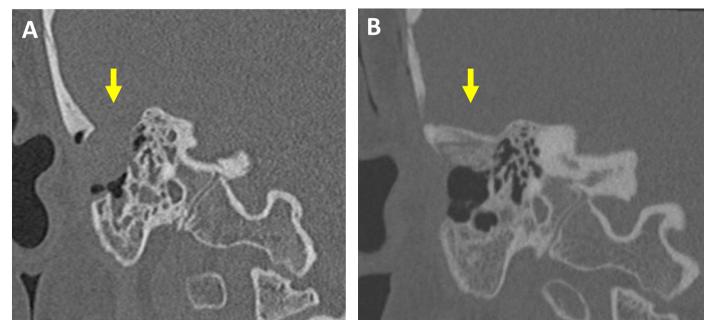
A. Pre-operative coronal temporal bone CT demonstrating tegmen mastoideum encephalocele. B. Post-operative imaging of same patient after multilayered repair.
